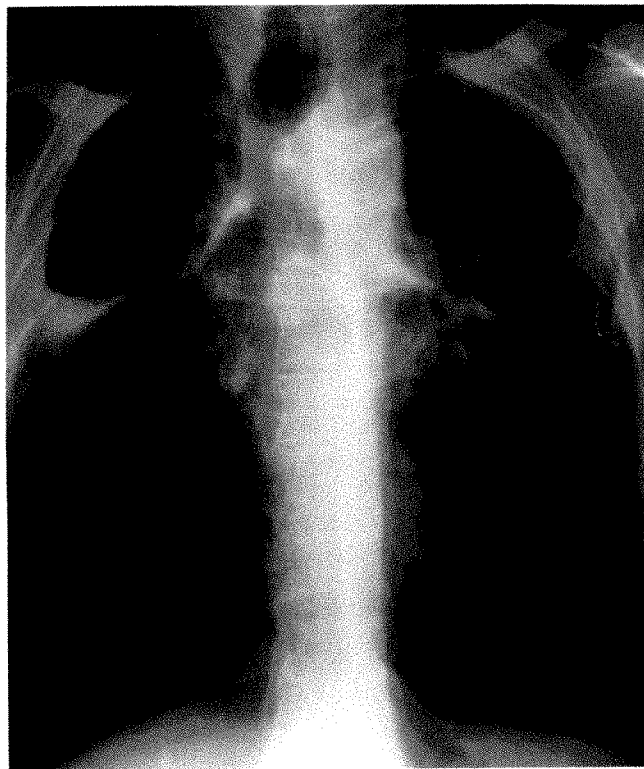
Posteroanterior chest radiograph reveals cavitary disease in upper lobes of a 59-year-old white male smoker with a history of chronic obstructive pulmonary disease. *Mycobacterium avium-intracellulare* pneumonia was diagnosed 2 years before by positive sputum cultures and was treated with isoniazid and rifampin for 1 year with poor response and continued positive sputum cultures. Weight loss, anorexia, fever, chills, and night sweats continued, and he became malnourished and cachectic. Purified protein derivative skin test remained negative.
